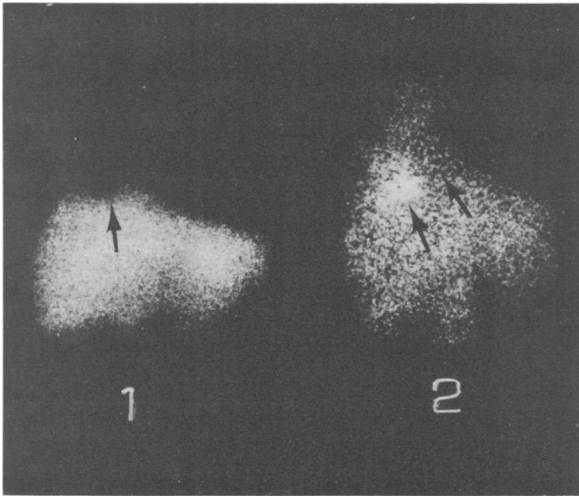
(Case 2) Anterior liver: Left, the ^{99m}Tc sulfur colloid scintigraph (1) shows a defect in the dome of the right hepatic lobe. Right, a ^{67}Ga citrate scintigraph (2) obtained in the same position shows ^{67}Ga localization at the same site with extension into the right subphrenic space and right chest.
